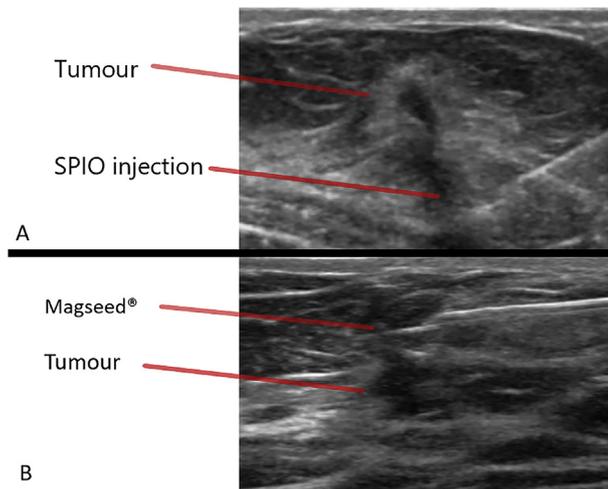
A. Breast Ultrasound with the lesion and SPIO injected dorsally. B. The Magseed® is injected and left on the ventral surface of the tumour.
